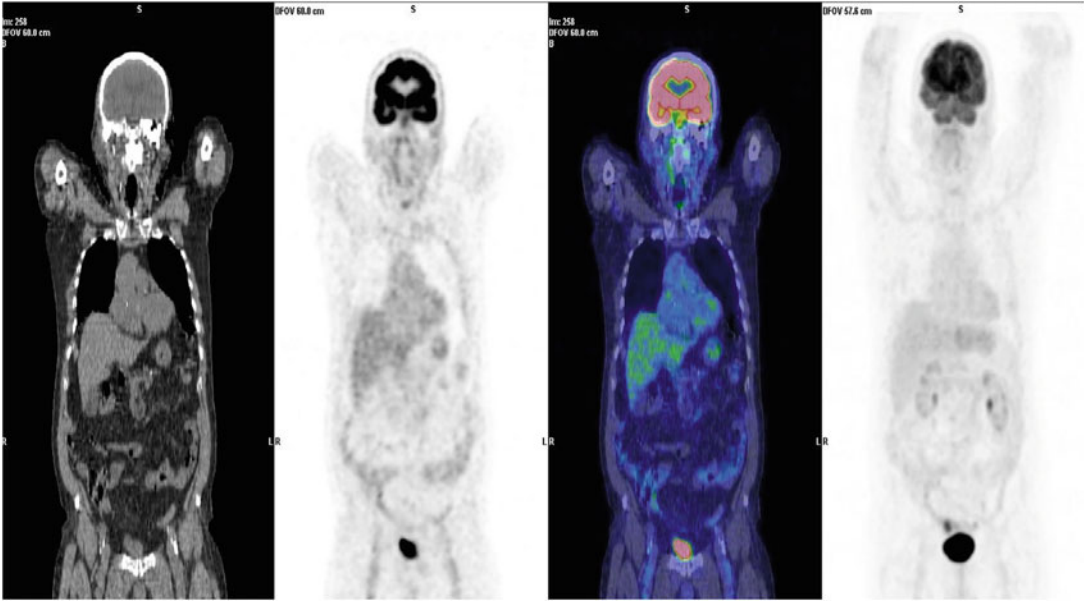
Physiologic biodistribution of [18F]FDG. In fasting and euglycemic conditions [18F]FDG uptake reflects GLUTs expression: [18F]FDG uptake is intense in brain, because of GLUT-3 expression that ensures correct glucose levels even in hypoglycemic conditions, weak in skeletal muscle for GLUT-4 expression
